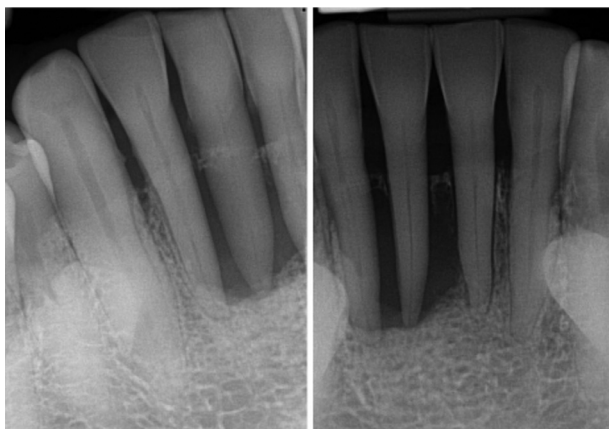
Periapical films show a sharply destructive lytic lesion around the incisor teeth. Note the sparing of the adjacent alveolar crest, which indicates the epicenter of the lesion is in the midroot area of the involved teeth.
